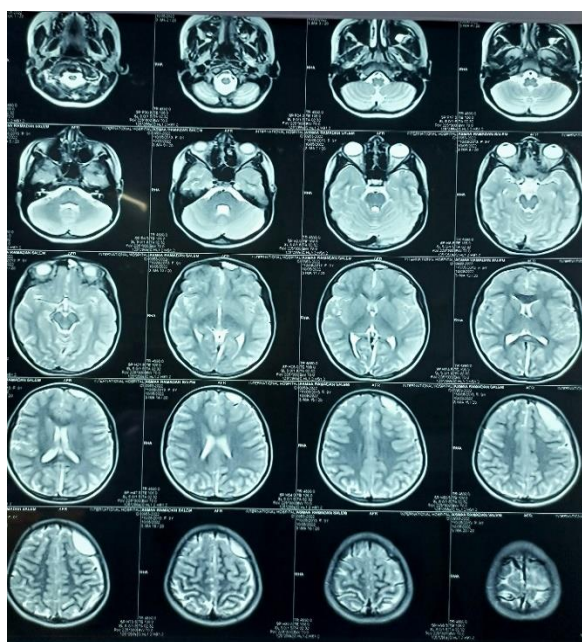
(3). MRI subdural empyema with no midline shift
